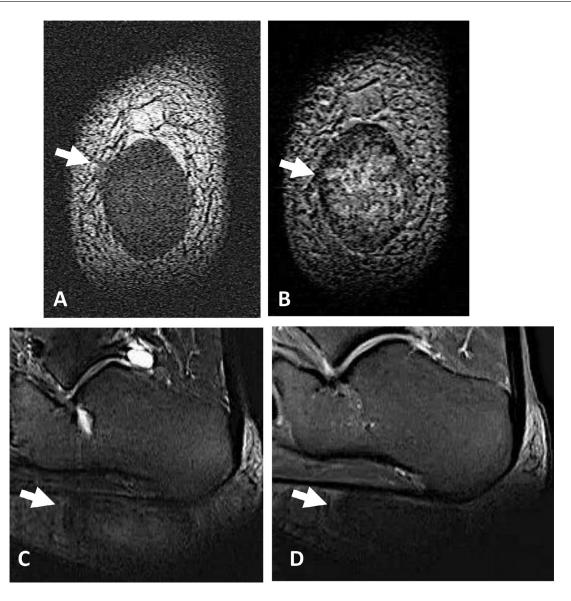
Multiplanar and multisequence MRI of the left hindfoot without and with gadolinium enhancement. (A) Axial T1 sequence demonstrates an ovoid soft tissue mass with low signal intensity, (B) Axial T2 fat sat sequence demonstrates heterogenous signal with peripheral low intensity, (C) Sagittal T2 fat sat, and (D) Sagittal T2 fat sat post gadolinium images showing no evidence of enhancement.
